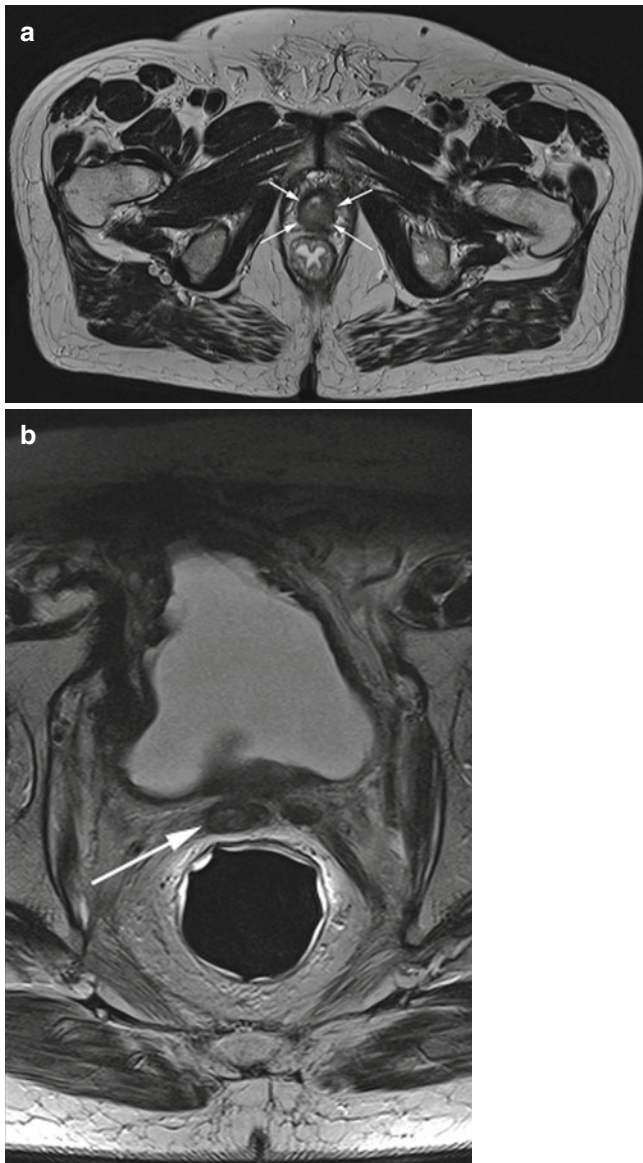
(a) A T2-weighted MRI axial slice of a local recurrence (white arrows) at the vesicourethral anastomosis following radical prostatectomy. (b) A T2-weighted MRI axial slice of a local recurrence (white arrows) at the seminal vesicle following primary radiotherapy
